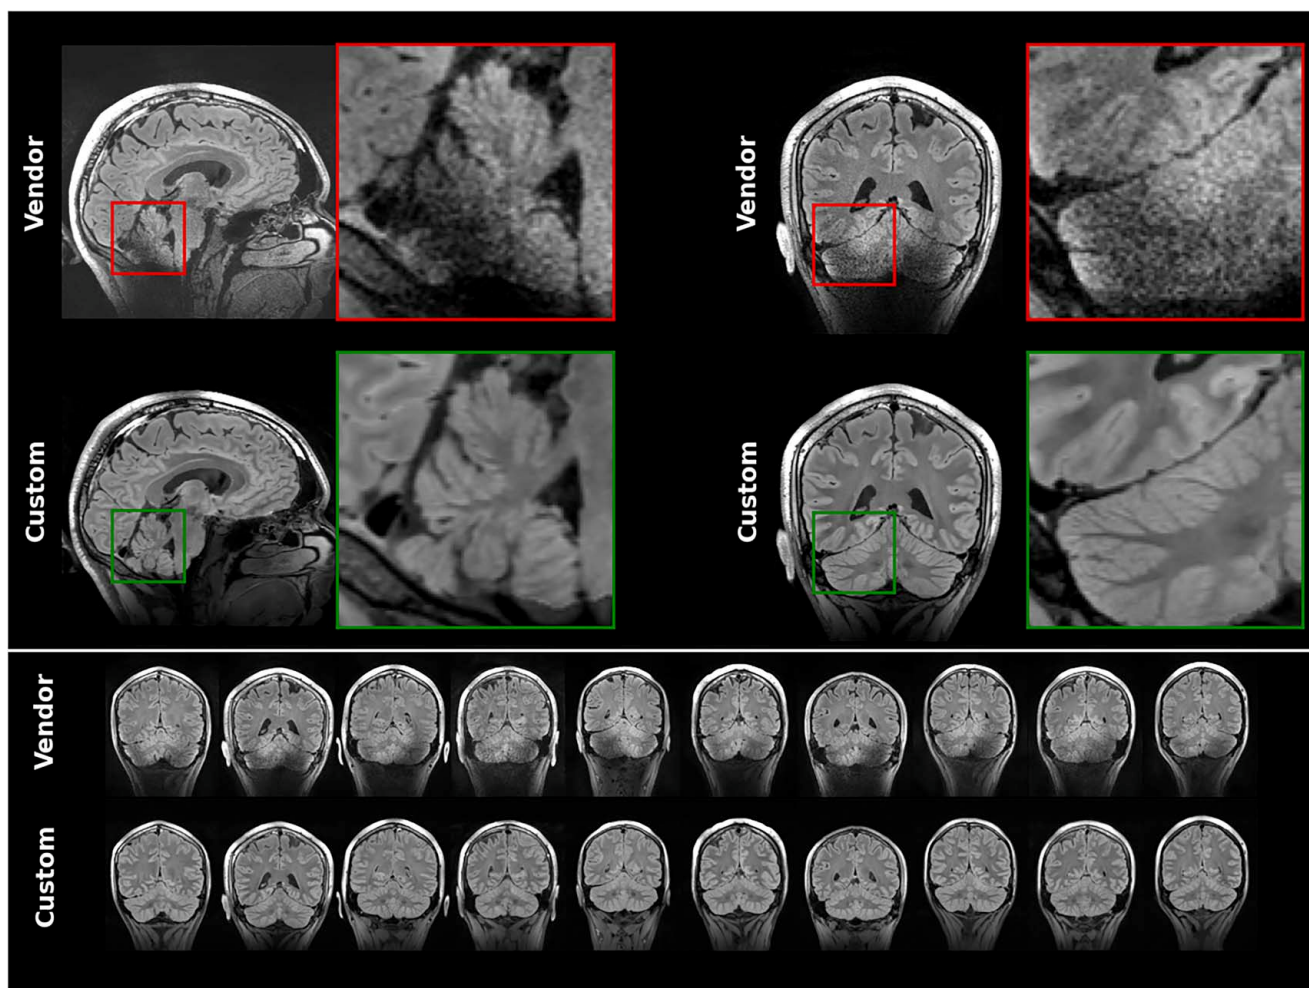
Intraindividual comparison of FLAIR images obtained with the vendor and custom sequences. The close-up views in the top panel highlight the superior image homogeneity and quality of the custom FLAIR. In the bottom panel, the coronal views of pairwise intraindividual comparisons demonstrate that image quality impairments due to CP-mode acquisition occurred consistently with the vendor sequence, whereas image quality and homogeneity could be improved reliably with the custom sequence in all healthy subjects.
